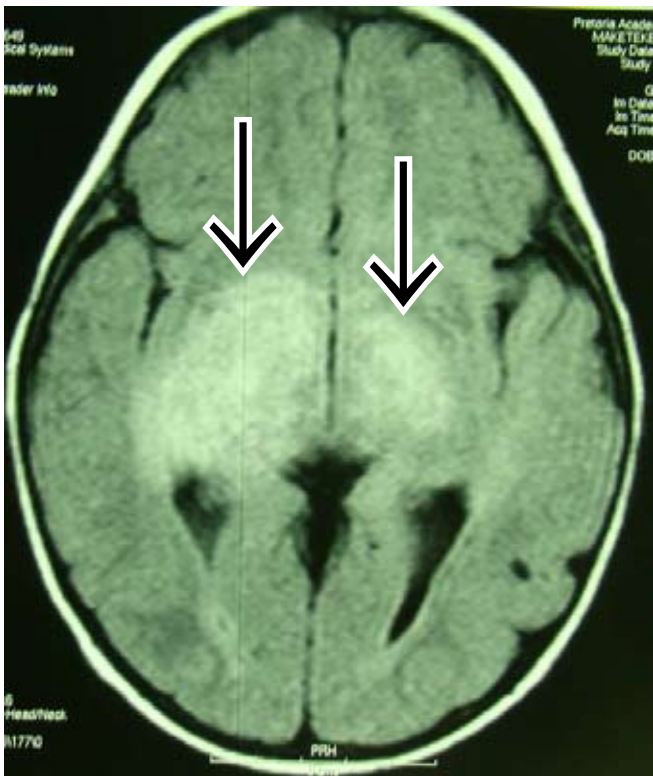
Axial FLAIR sequence of the same patient as above shows bilateral hamartomatous high signal changes in the basal ganglia (FASI) with no appreciable mass effect.
